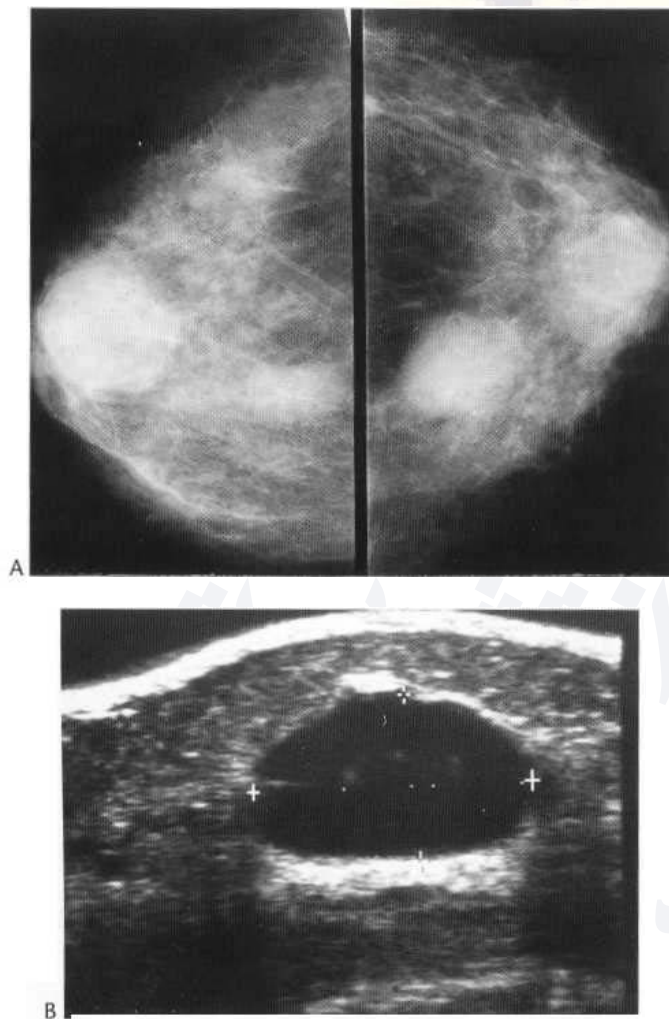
Simple cysts. (A) Multiple circumscribed low soft-tissue density lesions are seen in both breasts. (B) Ultrasound shows the typical features of a simple cyst—a well-defined anechoic lesion with posterior acoustic accentuation.
